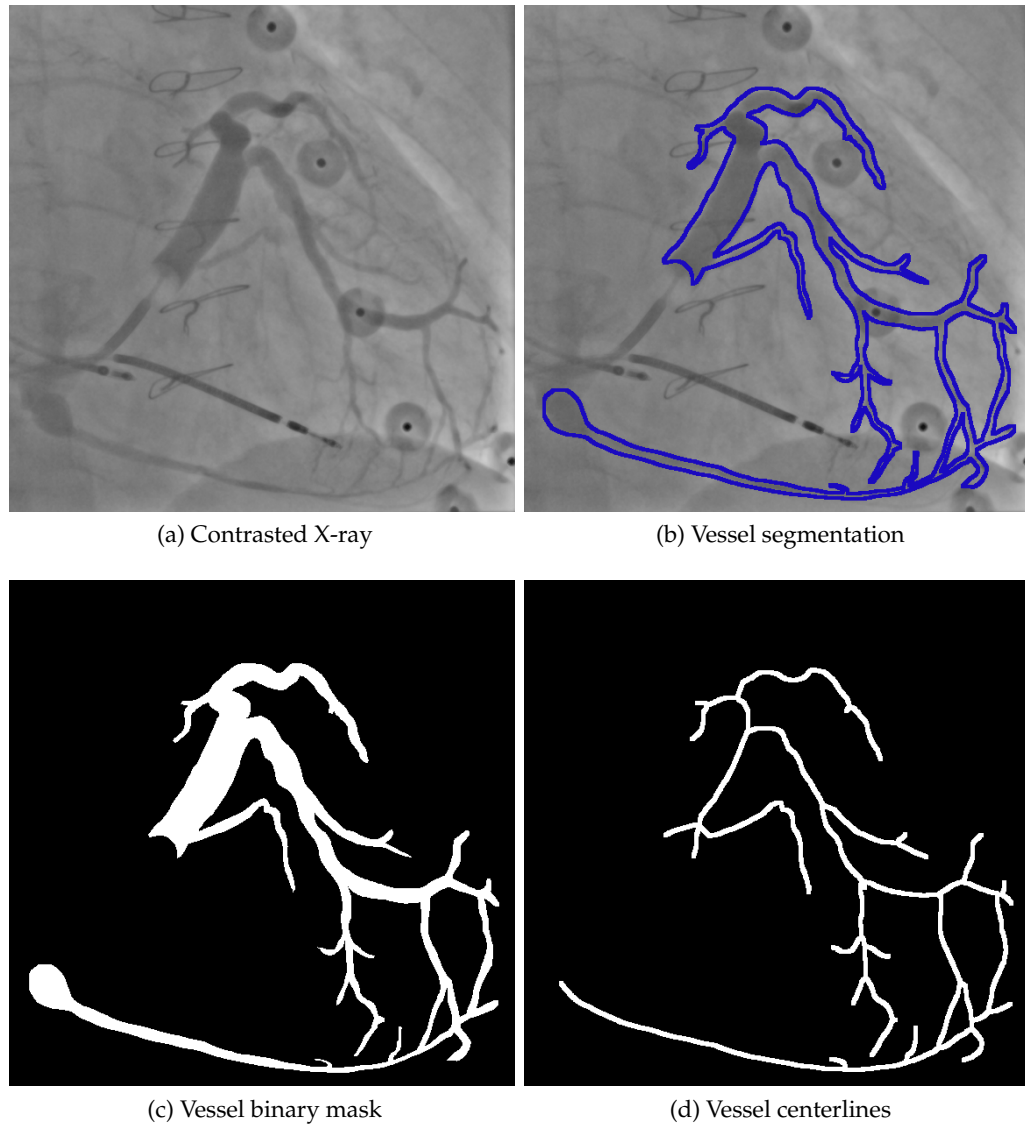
Vessel segmentation from contrasted X-ray images. (a) Initial contrasted X-ray frame. (b) Semi-automatic segmentation of coronary veins overlaid onto the frame. (c) Binarized segmentation image. (d) Extracted vessel centerlines represented by polylines.
